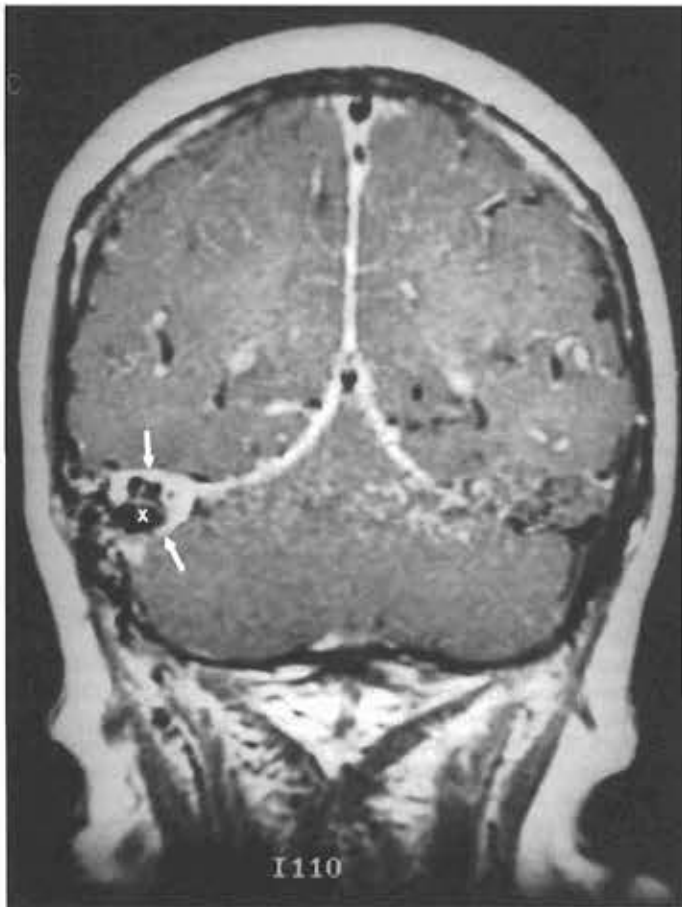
Coronal gadolinium-enhanced MRI of the brain showing a partially thrombosed transverse sinus. The dural AVM enhancement is indicated by the arrows, and the lumen is marked with an X.
